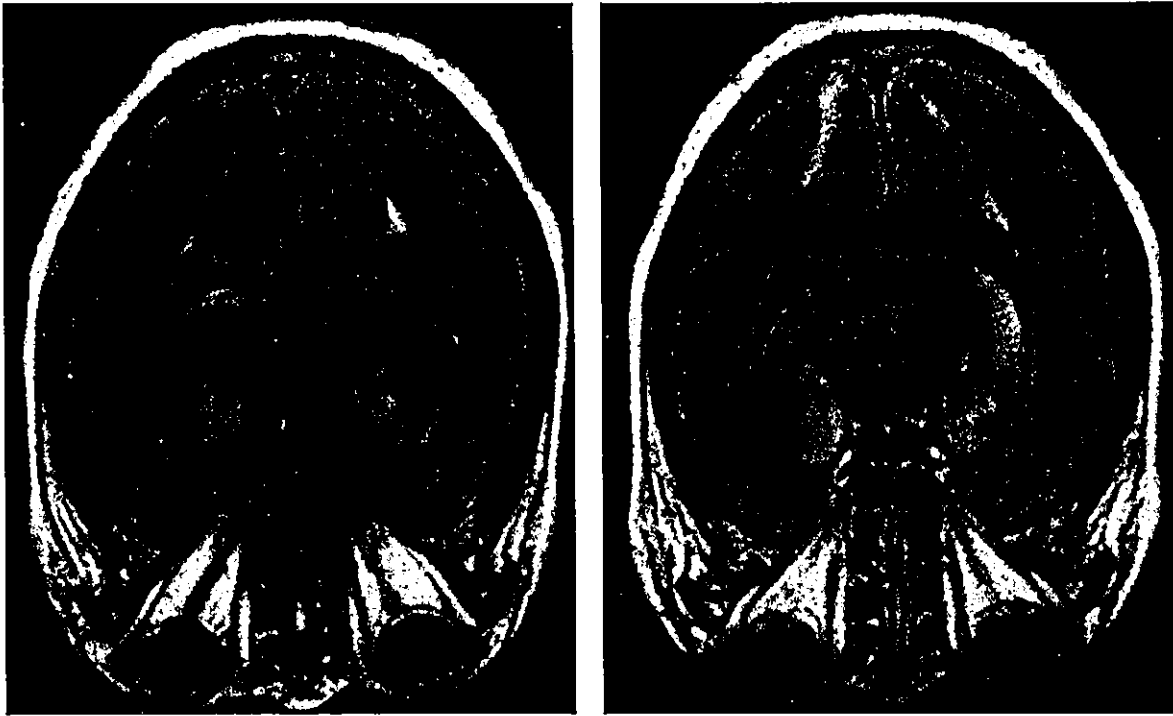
T2-weighted magnetic resonance image of the brain showing high-intensity signals in bilateral temporal lobes. The patient was diagnosed with limbic encephalopathy.
